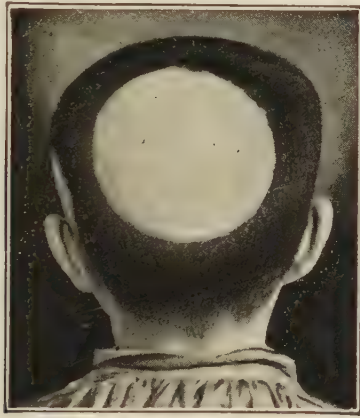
Alopecia due to x-ray exposure (*Sabouraud*).
